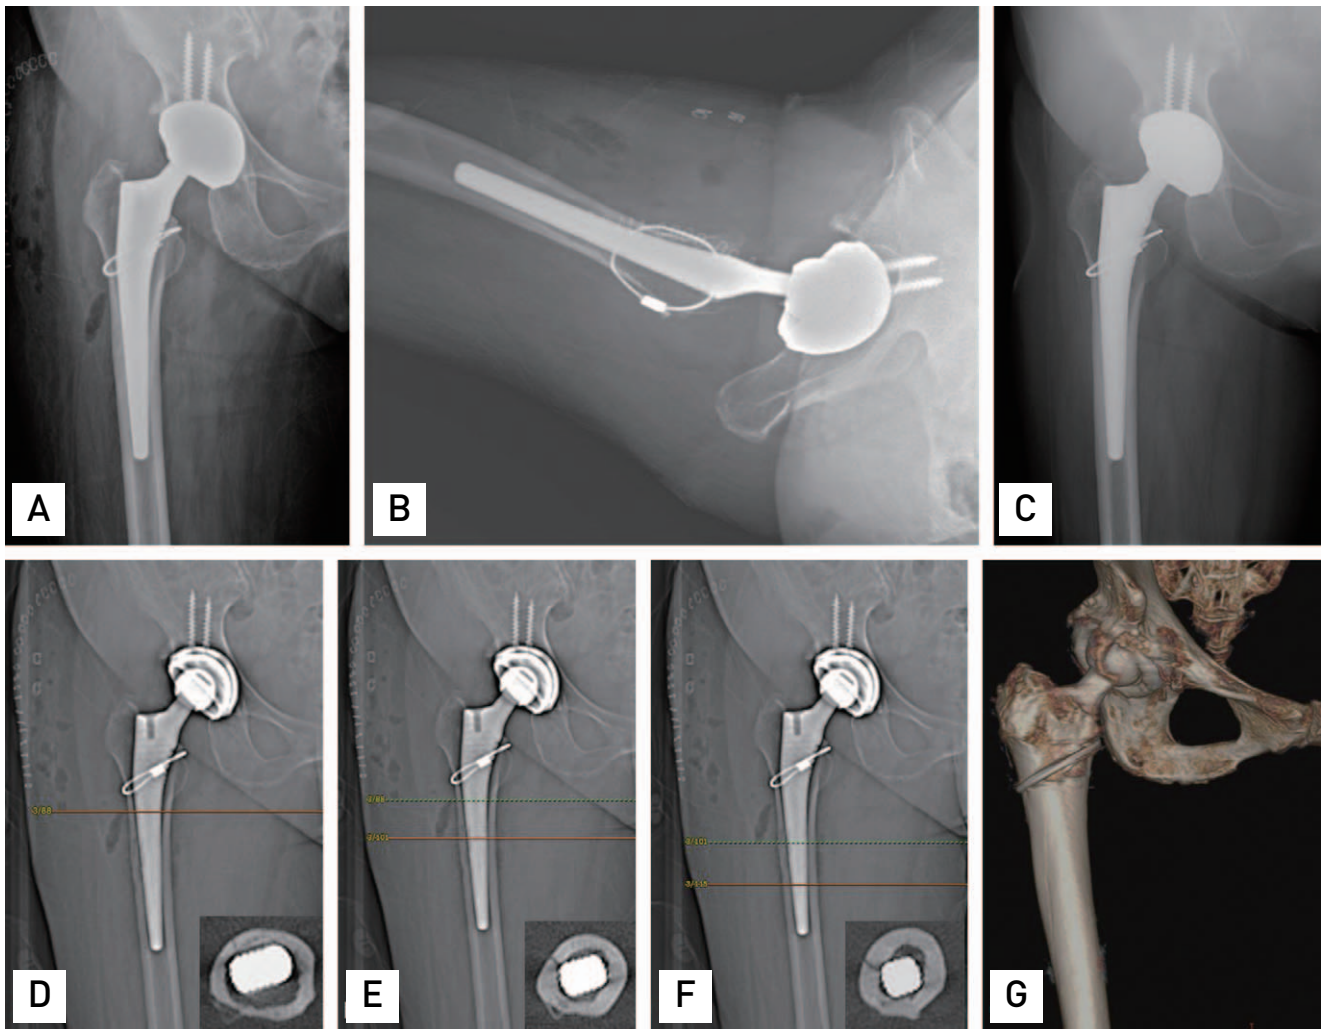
A 66-year-old female who underwent primary total hip arthroplasty using a Corail[®] stem. (A, B) Immediate postoperative radiograph. A type TL periprosthetic femoral fracture was detected during the operation and fixed by cerclage wiring. (C) One-year postoperative radiograph showed no abnormal findings in the right hip. (D-F) Immediate postoperative computed tomography (CT) images. (G) A periprosthetic occult femoral fracture that extended to the distal one-third of the femoral stem was observed concurrently on axial and three-dimensional CT reconstruction images at different levels.
